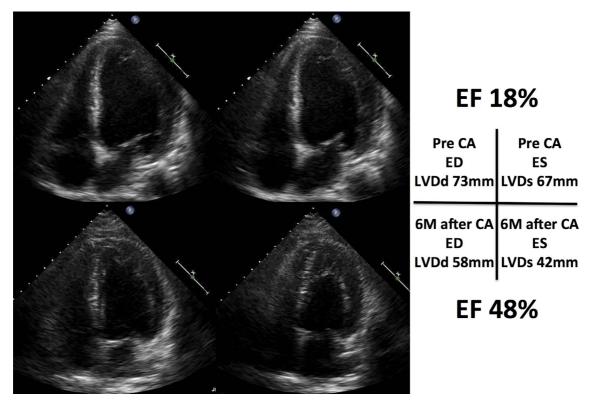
Transthoracic echocardiography before and 6 months after catheter ablation. The patient's left ventricular dyssynchrony resolved immediately after catheter ablation and his left ventricular function showed dramatic improvement at 6 months after catheter ablation. EF: ejection fraction, CA: catheter ablation, ED: end-diastolic phase, ES: end-systolic phase, LVDd: left ventricular diameter on diastole, LVDs: left ventricular diameter on systole, 6M: 6 months
